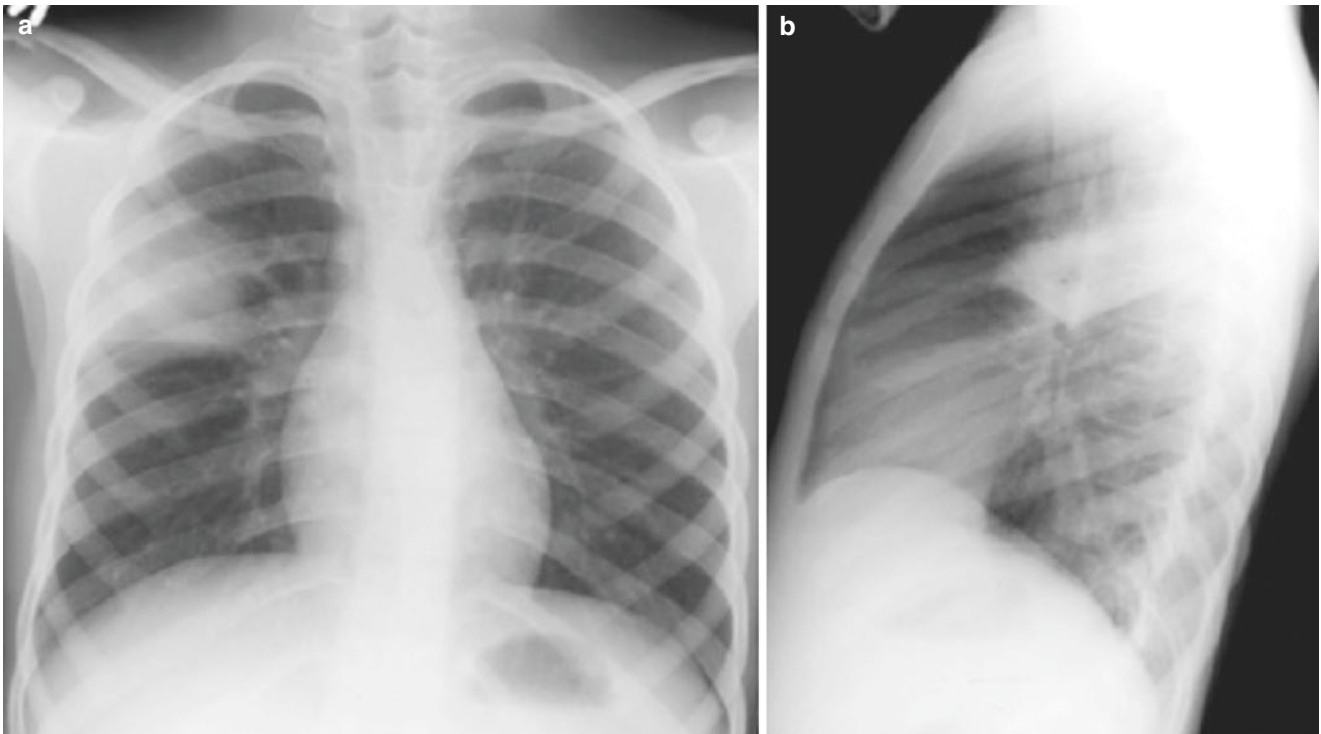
A 13-year-old boy who presented with cough and fever. (a) PA and (b) lateral radiographs demonstrate a dense consolidation in the right upper lobe abutting the major and minor fissures. Sputum cultures grew *Pneumococcus*, and the patient became well on penicillin therapy
